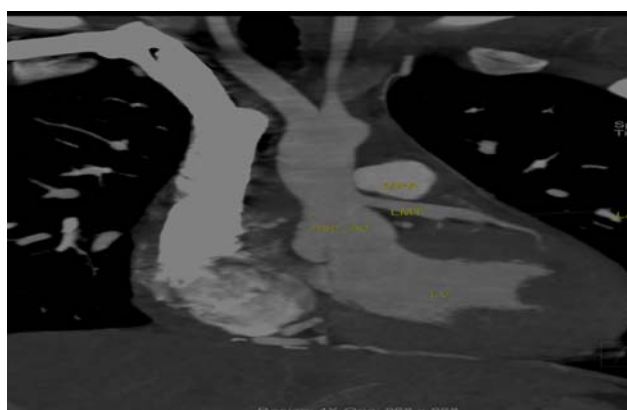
(b). Postoperative coronal section of CT scan showing the origin of LMCA from the aorta after its re-implantation.
